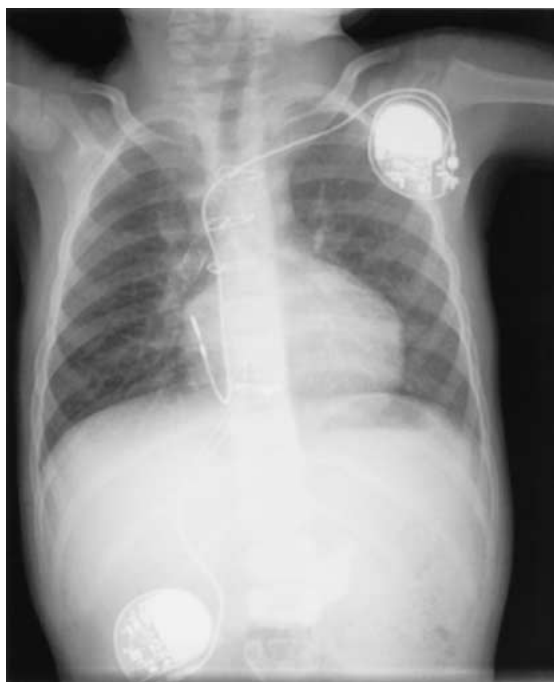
Follow-up chest x-ray, 2 months after implantation of AAI pacemaker, demonstrating marked improvement, with basically clear lung fields and only mild residual scarring/atelectasis and the right lower base.
